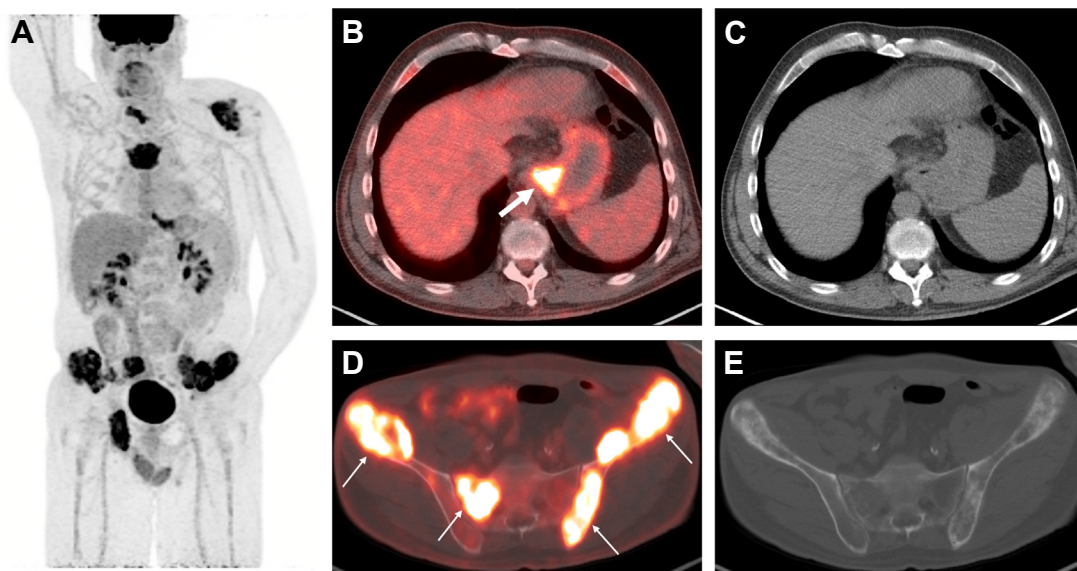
A 52-year-old-man with gastric adenocarcinoma. ¹⁸F-FDG PET/CT maximum intensity projection image (A) shows extensive hypermetabolic metastatic disease. The trans-axial fused PET/computed tomography (CT) and CT images show the hypermetabolic primary lesion involving the gastric cardia and the distal esophagus (*thick arrow*; B, C) with multifocal osseous metastases, including both the iliac bones and the sacrum (*thin arrows*; D, E).
